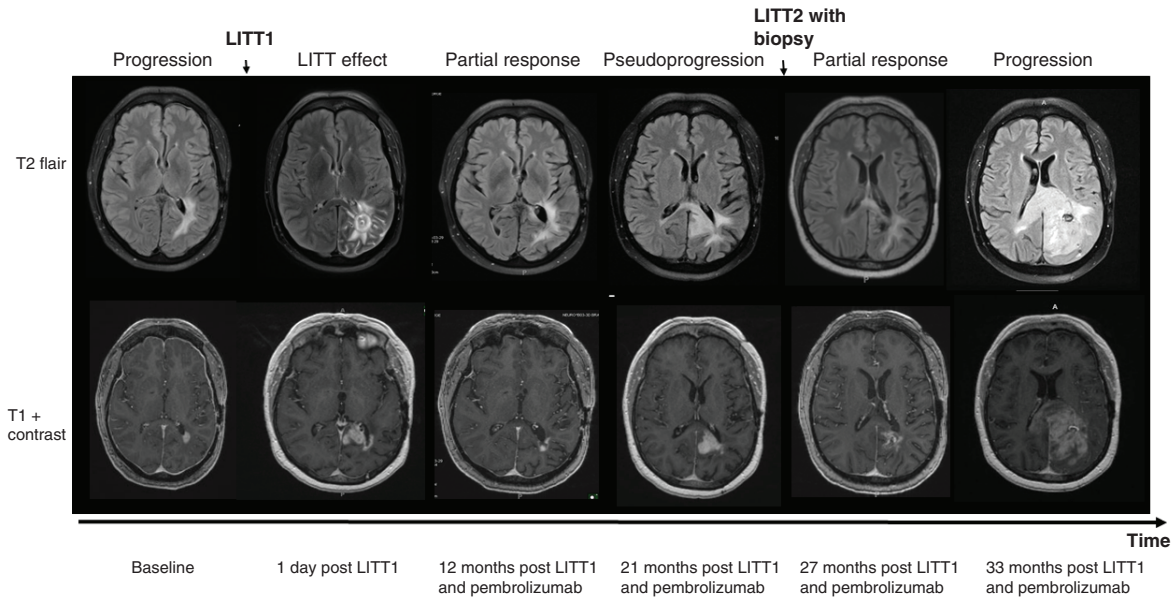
T2-weighted-Fluid-Attenuated Inversion Recovery (T2/FLAIR) (upper panel) and T1 weighted contrast enhancement (lower panel) brain MRI images taken at different times before and after laser interstitial thermal therapy treatment for patient 1. The patient’s baseline scan showed tumor progression. He received LITT followed by pembrolizumab. Pseudoprogession was noted and tested by repeat LITT with biopsy. Partial response was seen in the subsequent scans. The patient’s last MRI showed further progression of disease. LITT: Laser interstitial thermal therapy.
